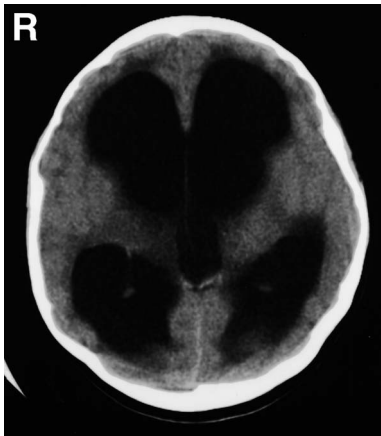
Computed tomography scan obtained on first admission at another hospital demonstrating marked hydrocephalus.
